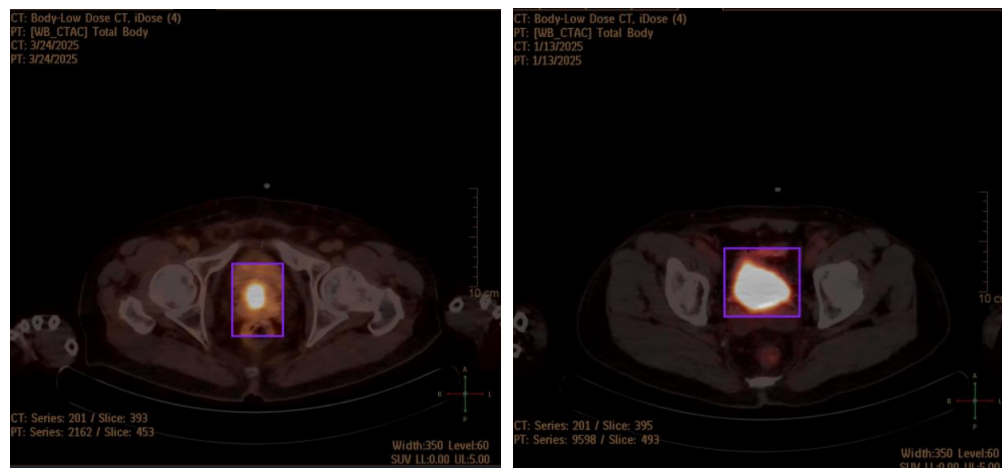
Annotated PET/CT cuts showing the highlighted prostate cancer region
